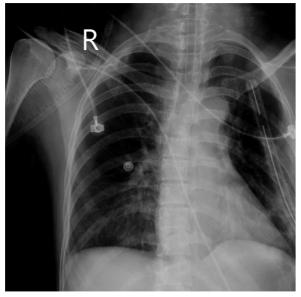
Chest X-ray shows increased density in the retrocardiac region with a tube inserted into the left pleural cavity (arrow).
